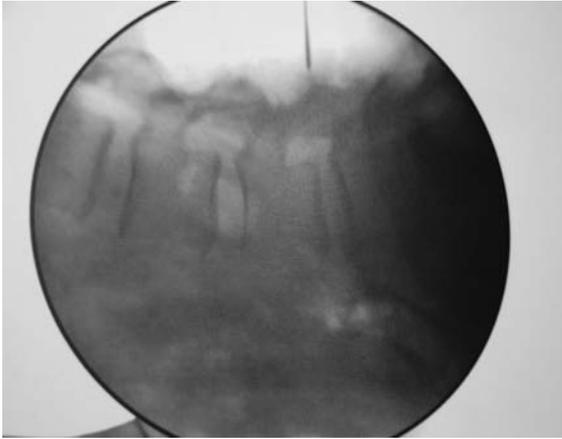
Radiographic image of proper placement and angle on lateral radiograph for the appropriate level.
